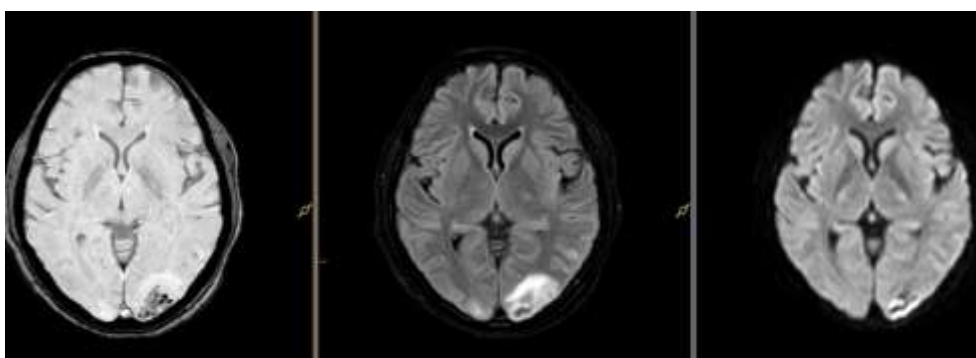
Axial MRI images (SWI, FLAIR and DWI) demonstrate a focal hemorrhagic lesion in the left occipital lobe with surrounding cortical–subcortical edema, consistent with haemorrhagic involvement in posterior reversible encephalopathy syndrome.
